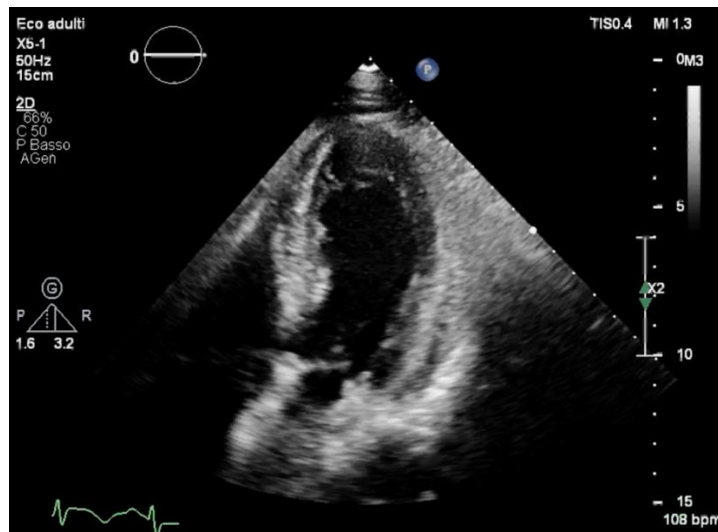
Echocardiogram showing apical ballooning
